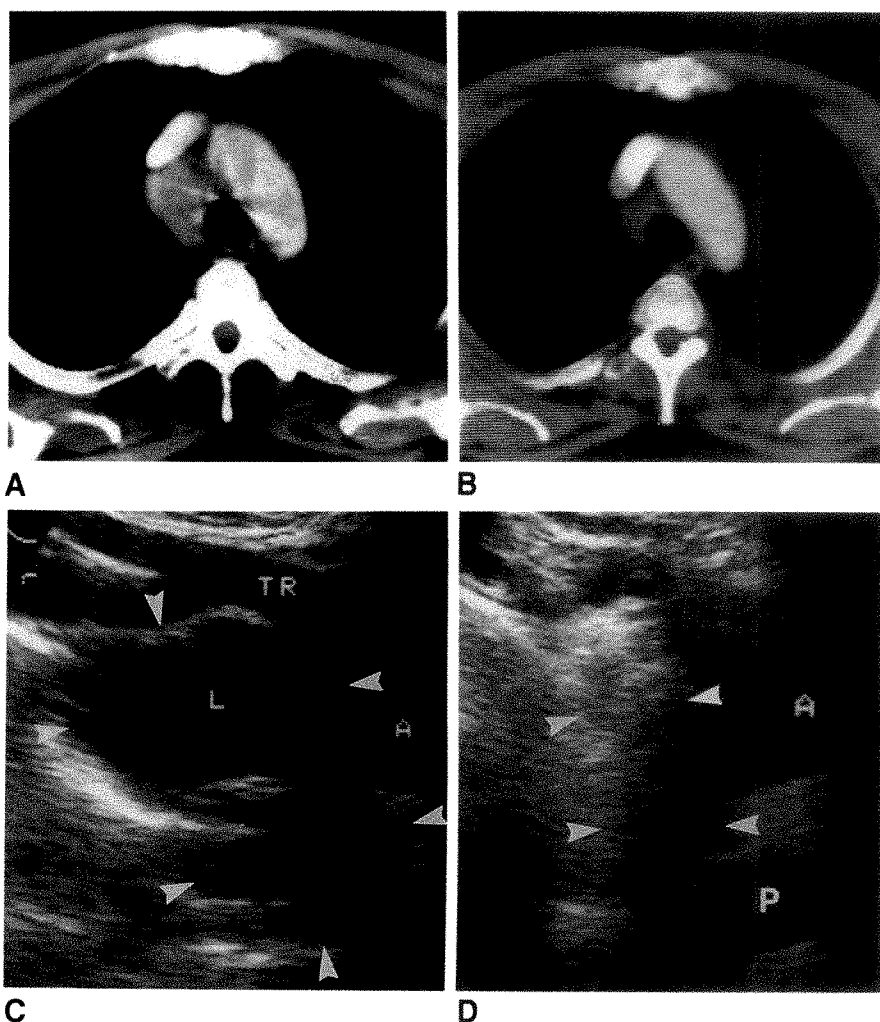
CT and sonographic follow-up in a 63-year-old woman with non-Hodgkin lymphoma and incomplete remission.
